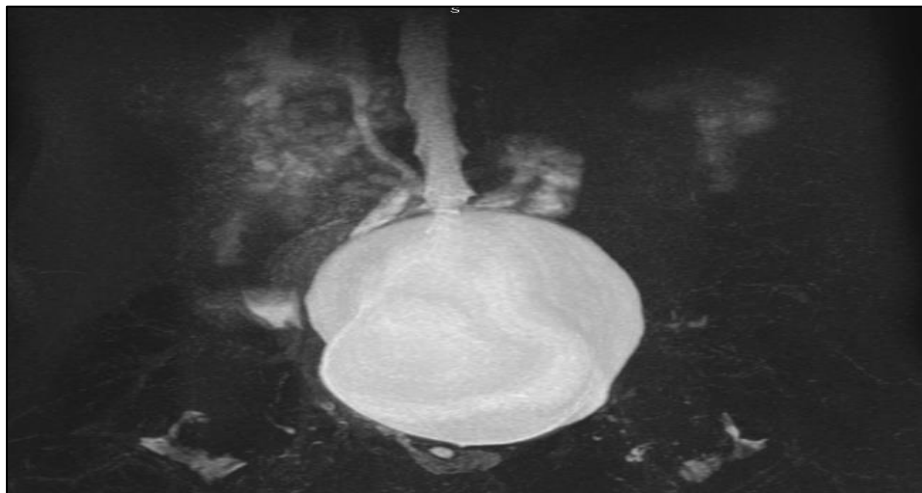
Coronal MRI Showing Renal Agenesis on Left Side with Compensatory Hypertrophy of Right Kidney.
